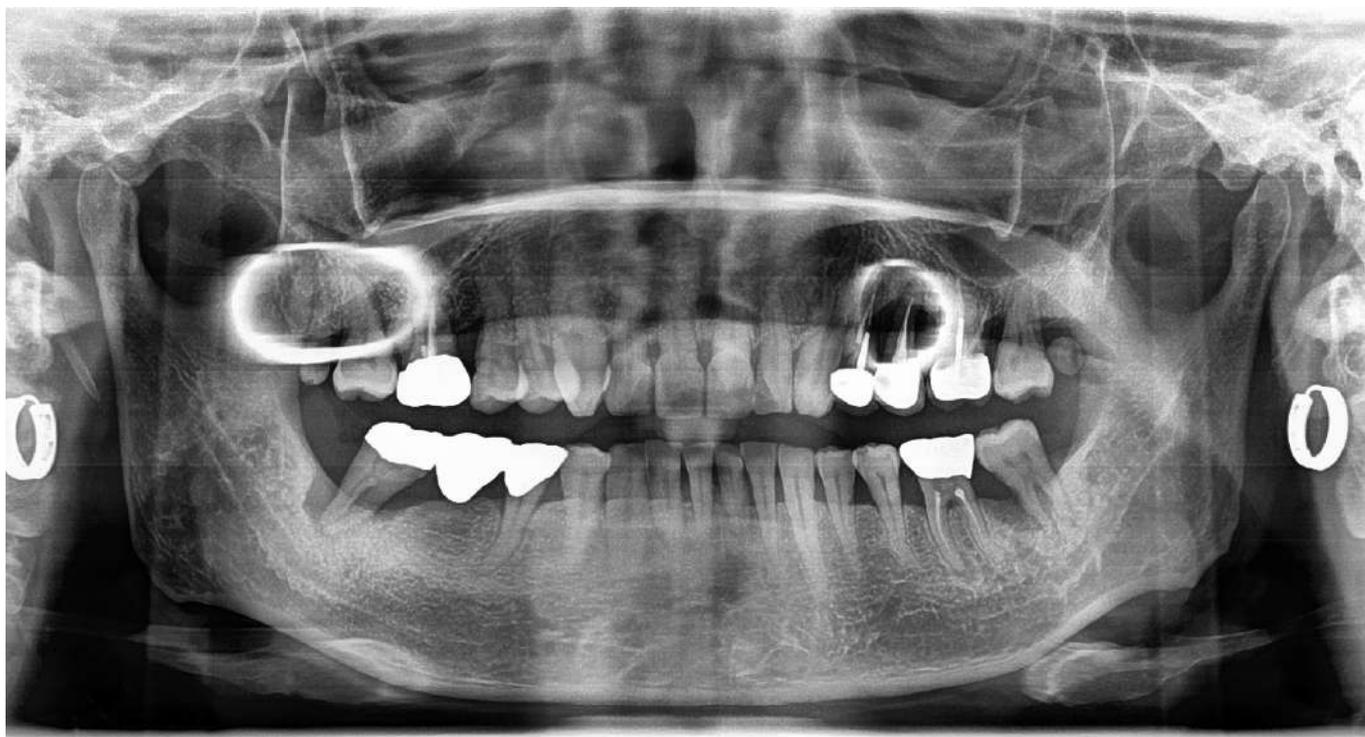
Pre-operative panoramic X-ray
